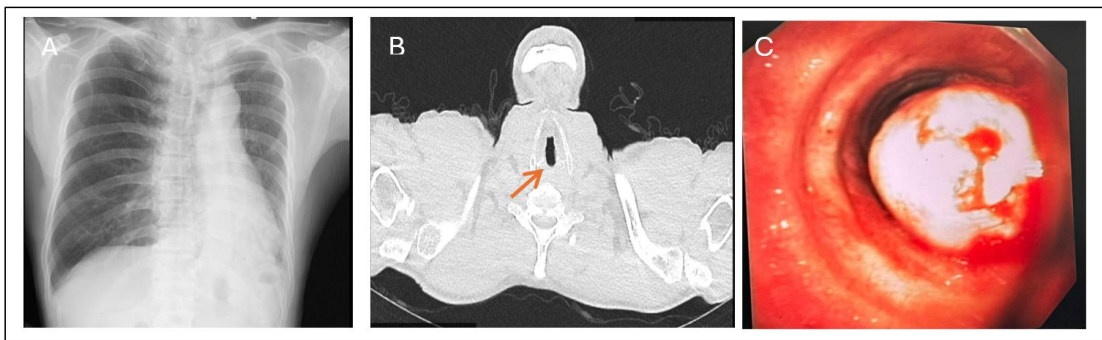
Preoperative diagnostic evaluation of Patient 1. (A) Chest radiograph; (B) Thoracic CT scan showing narrowing of the tracheal lumen (red arrow); (C) Bronchoscopic findings demonstrating a mass in the distal third of the trachea
